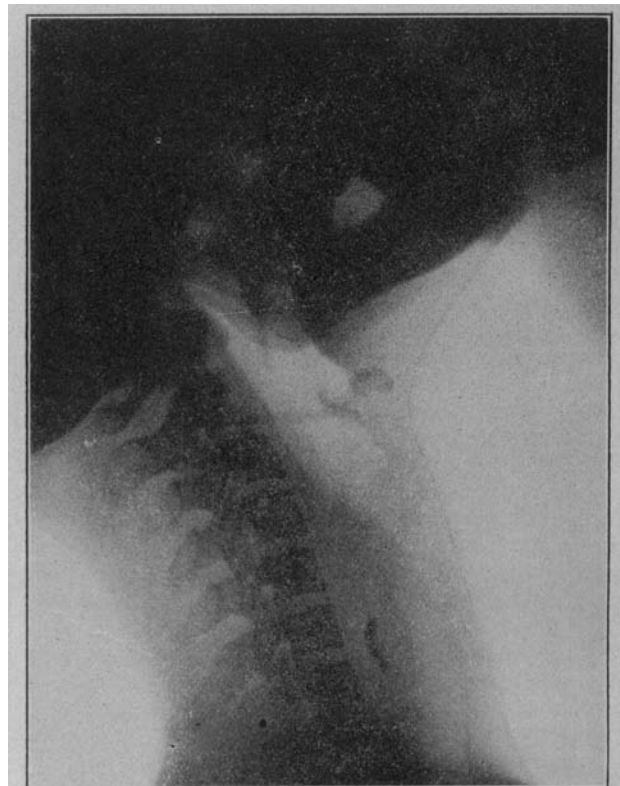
Radiograph by Dr. George C. Johnston, showing bone in the esophagus. Note the swelling of the esophageal walls and the clear outline of the air passages.
